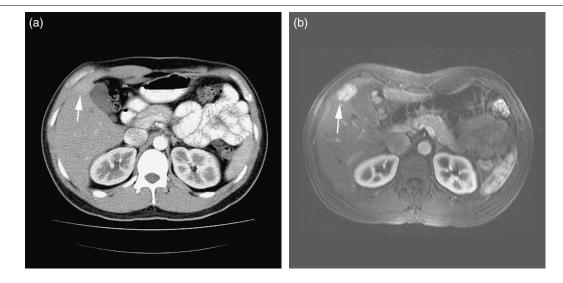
HCC. (a) Arterial phase helical CT shows a slightly hyperdense lesion (arrow). (b) Arterial phase T1-weighted fat-suppressed 3D gradient-echo scan shows the hypervascularity (arrow) better than CT.
